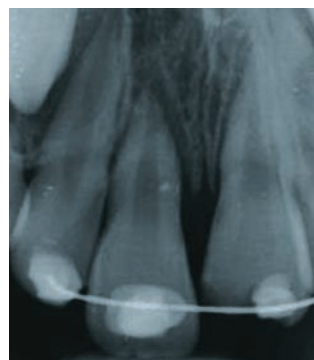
Background: An eight-year-old boy avulses the upper right permanent central incisor and sustains a complicated crown fracture to the maxillary left permanent central incisor. The extra oral time of 11 was greater than one hour. The PDL was removed and the tooth soaked in sodium fluoride for 20 minutes. The tooth was replanted and a flexible splint placed. The periapical radiograph shows the position of the 11 following replantation.
